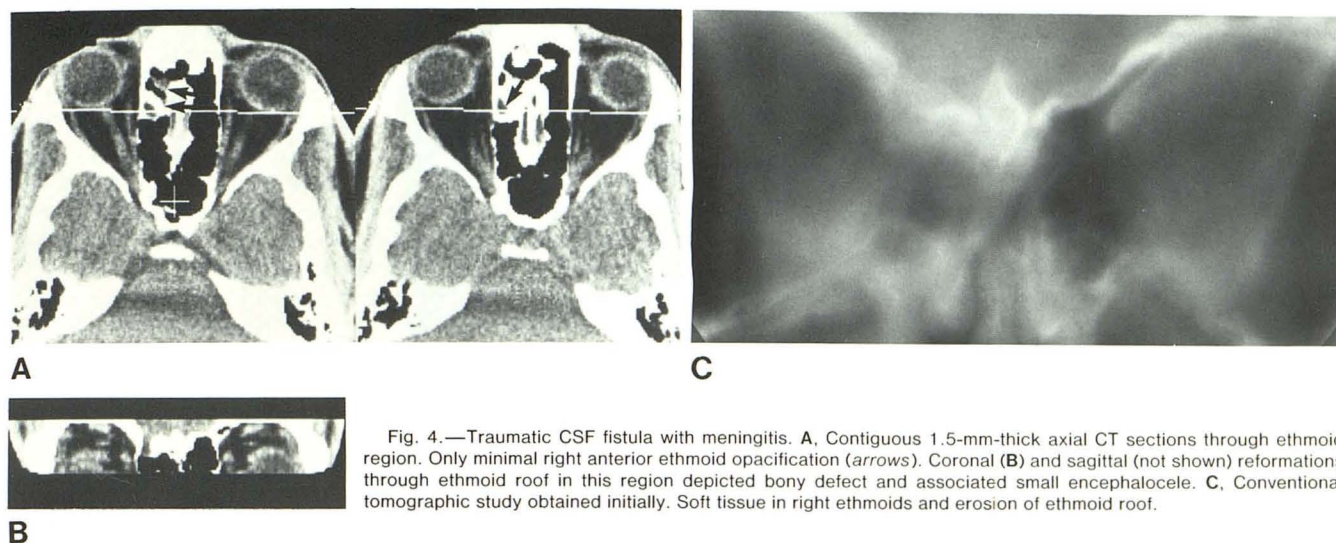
Traumatic CSF fistula with meningitis. A, Contiguous 1.5-mm-thick axial CT sections through ethmoid region. Only minimal right anterior ethmoid opacification (arrows). Coronal (B) and sagittal (not shown) reformations through ethmoid roof in this region depicted bony defect and associated small encephalocele. C, Conventional tomographic study obtained initially. Soft tissue in right ethmoids and erosion of ethmoid roof.
